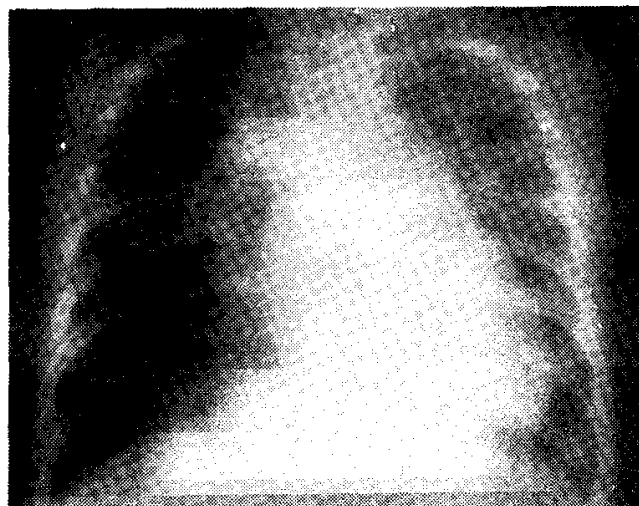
X-ray chest of a 5-year-old child with PDA showing cardiomegaly, pulmonary plethora and a dilated pulmonary artery; the straight line sign is obliterated.
